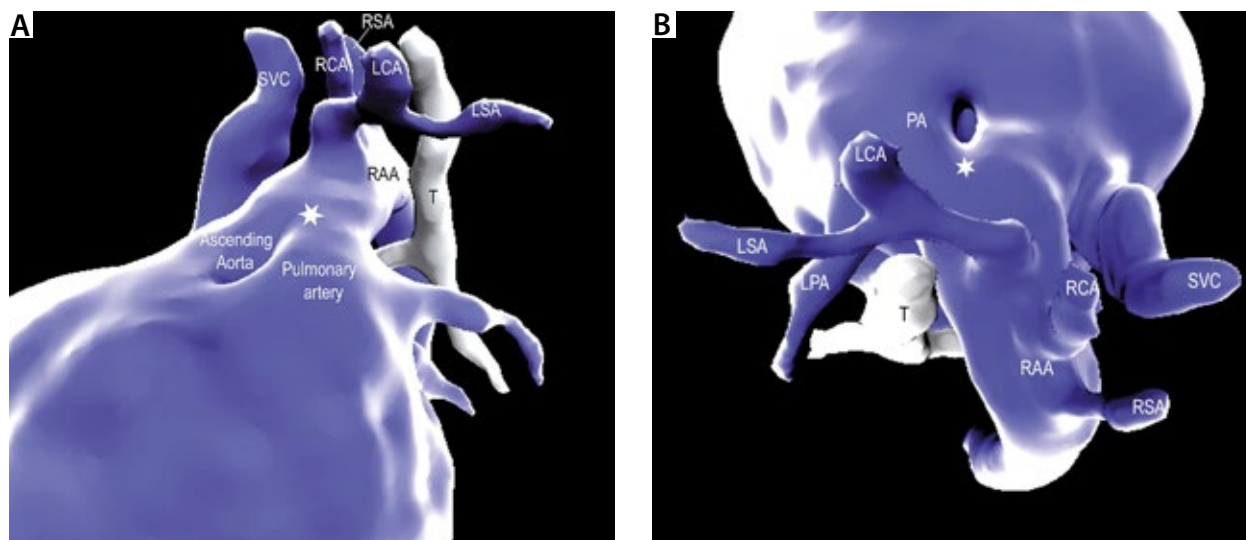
Fetal cardiac MRI demonstrates the anatomy in 3D using motion-corrected segmentation. The left lateral view (A) and the superior view (B) show the right-sided aortic arch with mirror image head and neck artery branching and a large communication between the main pulmonary artery and the proximal aorta. There is no arterial duct present
